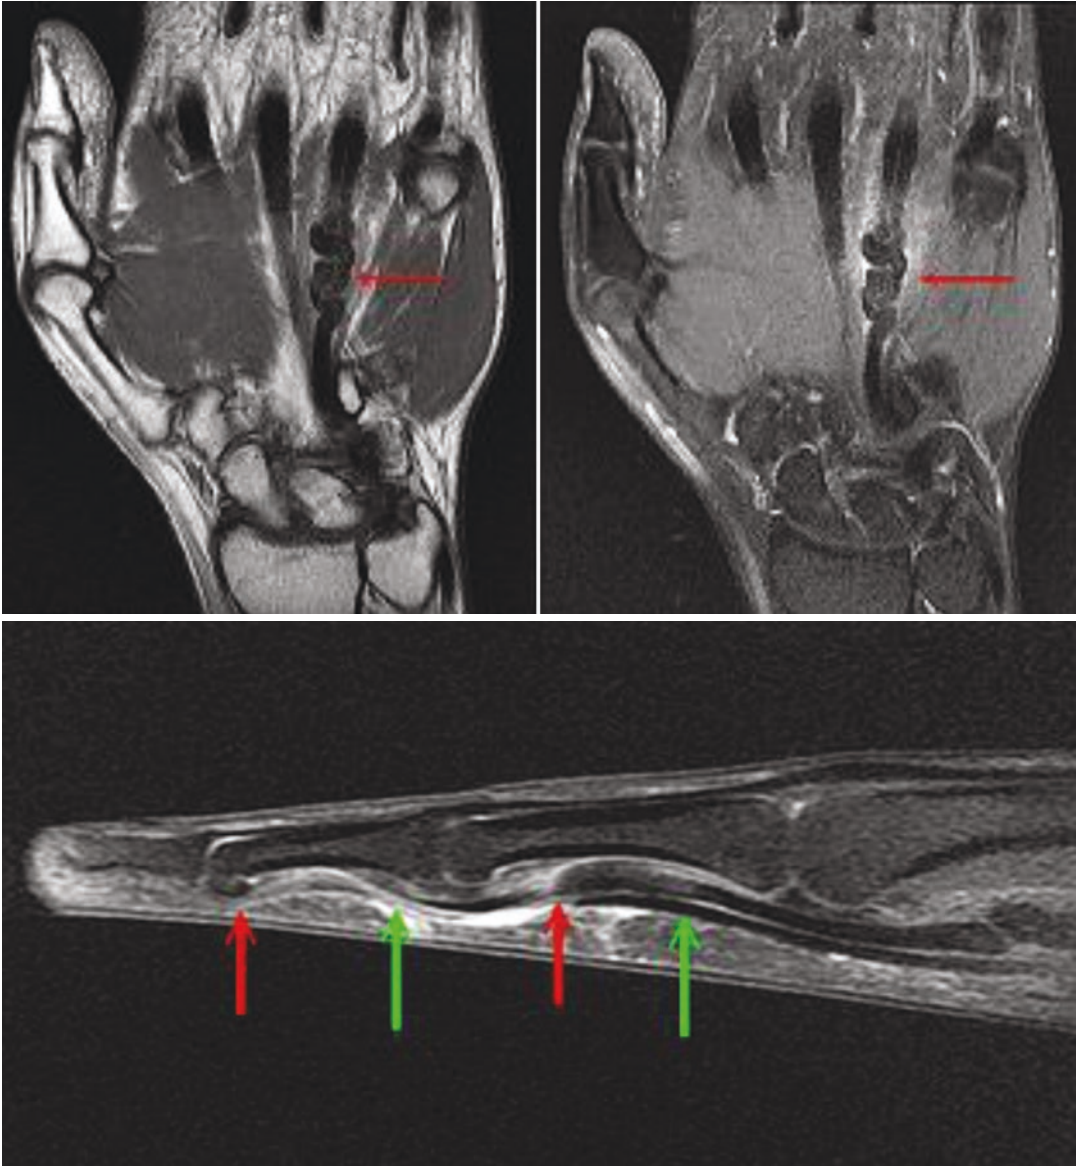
MRI of FDP avulsion
